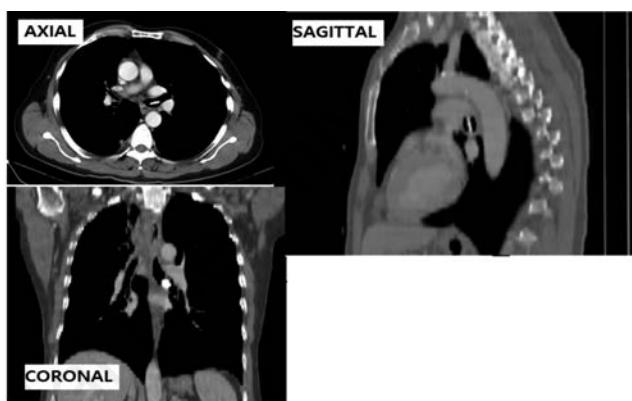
Computed Tomography (CT) images of Foreign Body (FB).
